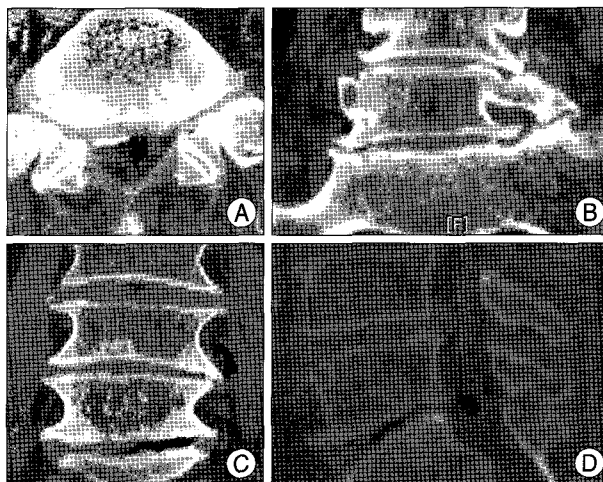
A : Axial lumbar computed tomography (CT) demonstrated an air pocket in the spinal canal with bulging disc and ossification of annulus at 5th Lumbar to 1st sacral disc space. B : Vacuum of right L5-S1 foramen, eccentric small amount of intradiscal air and degenerative osteophyte were seen in coronal reconstructed CT. C : Air pocket of left psoas muscle, eccentric location of small amount of intradiscal air at L4-5 disc space and degenerative osteophyte were seen in coronal reconstructed CT. D : Sagittal reformatted images showed the linear track of vacuum adjacent to upper endplate through the intervertebral disc to epidural space at L5-S1.
